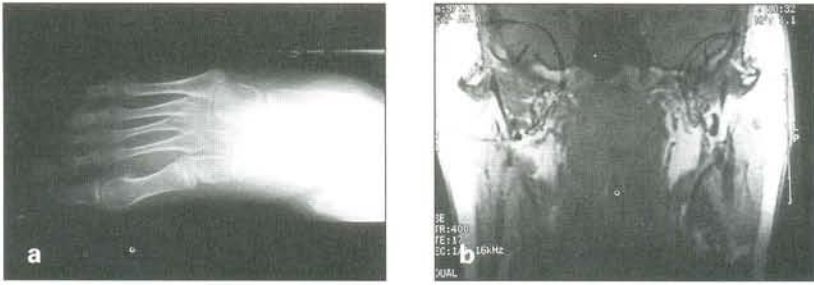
(a) Foot radiograph. (b) MRI showing the disc replaced by fat.
